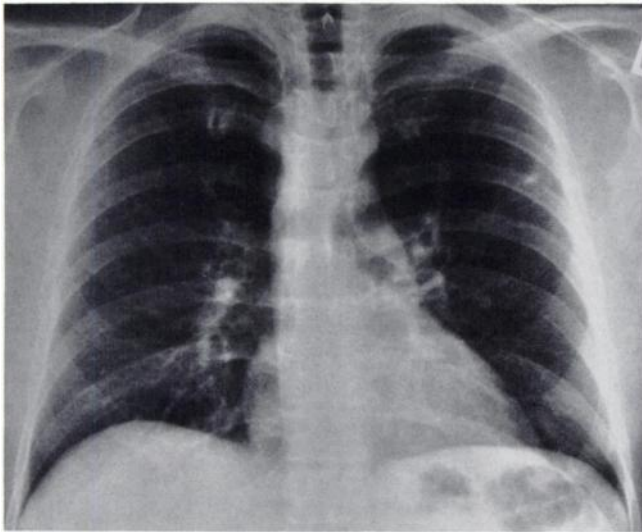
PA chest radiograph demonstrating protrusion of the aortic knob from the right side of the upper mediastinum along with leftward tracheal deviation. The descending aorta is seen along the right side of the thoracic spine.
